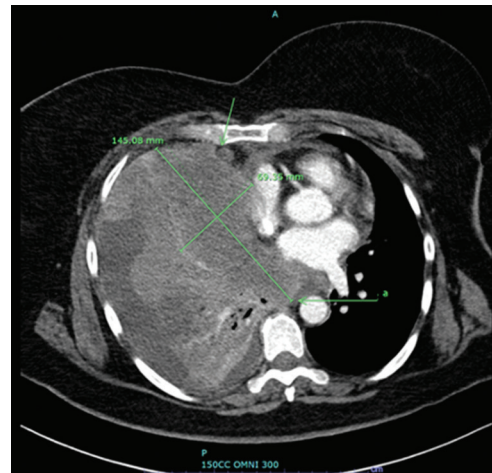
Computed tomography of the thorax in the axial plane shows a 14.5 × 6.9 cm mass arising from the mediastinum, which invades the anterior chest wall and causes significant superior vena cava stenosis.
